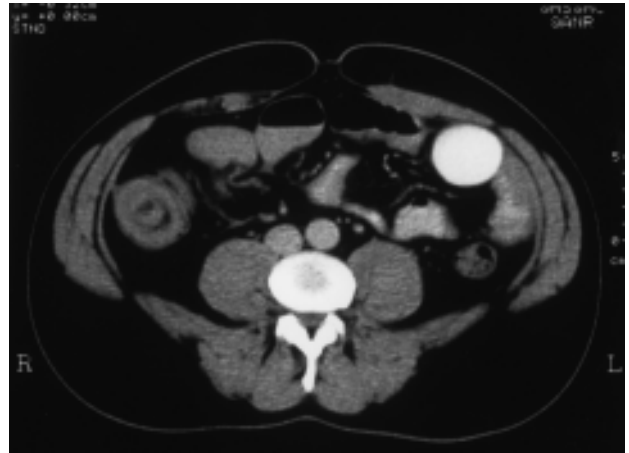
CT scan demonstrates the three concentric circles characteristic of intussusception.
